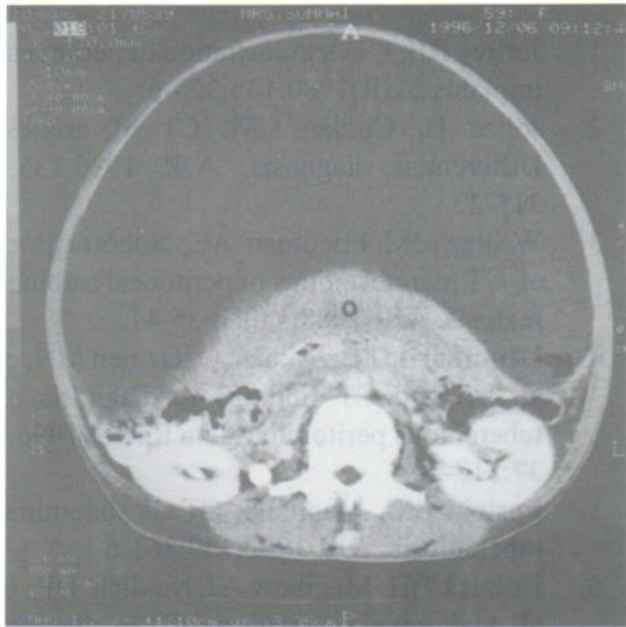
Carcinomatosis peritonei due to metastatic adenocarcinoma in 59-year-old woman. Contrast-enhanced CT scan shows massive ascites, omental cake (O) and thickened, enhanced parietal peritoneum (arrow).
